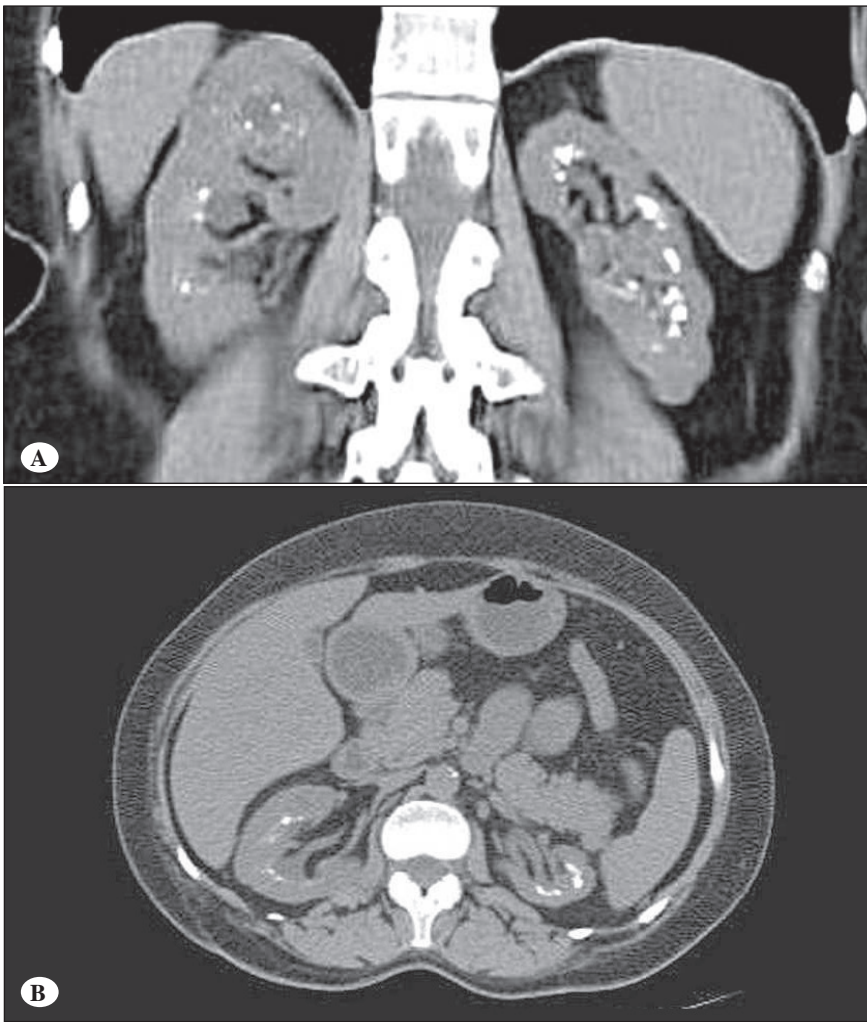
A,B) Abdominal computed tomography sections of the patient with medullary sponge kidney revealing multiple punctuated calcifications aligned concentrically in the medulla of the kidneys.
